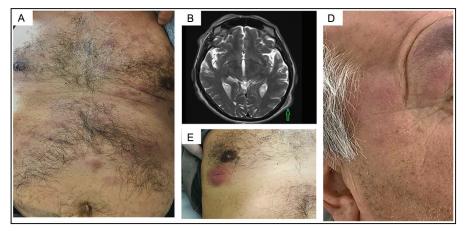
Dermatologic examination revealing widespread erythematous nodules involving the anterior chest (A), most prominent on the right inframammarian area (C) and the right face (D). T2-weighted magnetic resonance imaging showed iso-hyperintense lesions in the left temporoparietal area (arrow, B)
